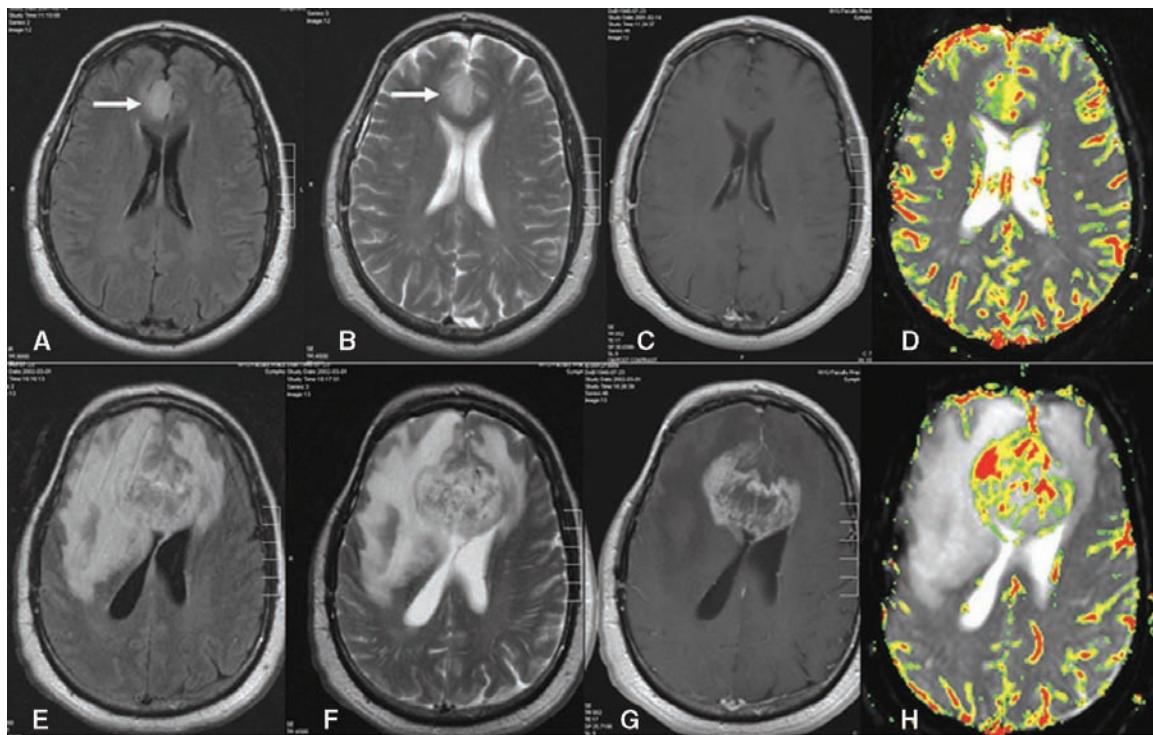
A 53-year-old male with pathology proven low-grade mixed oligoastrocytoma with a high baseline rCBV (4.29). Top Row (A) Axial FLAIR image [9000/110/2500(TR/TE/TI)]. (B) Axial T2-weighted image (3400/119) shows increased signal within the right mesial frontal lobe (arrow) with some mass effect on the adjacent genu of the corpus callosum. (C) Contrast-enhanced axial T1-weighted image (600/14) demonstrates no appreciable enhancement compatible with an imaging and pathologic diagnosis of LGG. (D) Gradient-echo (TR/TE 1,000/54) axial DSC MRI image, with rCBV color overlay map, shows a lesion with high initial perfusion with an rCBV of 4.23 more in keeping with an HGG than an LGG. Bottom Row (E) MRI at 127 days (18 weeks) follow-up. Axial FLAIR image [9000/110/2500(TR/TE/TI)]. (F) Axial T2-weighted image (3400/119) shows a substantial increase in tumor volume and volume of T2 signal abnormality by 220.97 cm³. There is now obvious evidence of tumor crossing the corpus callosum to the contralateral left frontal lobe. (G) Contrast-enhanced axial T1-weighted image (600/14) demonstrates an increase in enhancing tumor volume by 58.23 cm³. There is also more mass effect with almost complete effacement of the frontal horns. (H) Gradient-echo (TR/TE 1,000/54) axial DSC MRI image, with rCBV color overlay map, demonstrating progressively increasing rCBV from 4.23 to 13.37. Abbreviations: FLAIR, fast fluid-attenuated inversion recovery; LGG, low-grade glioma; DSC MRI, dynamic susceptibility contrast MRI; rCBV, relative cerebral blood volume; HGG, high-grade glioma; TR, repetition time; TE, echo time. Source: From Ref. 39.
